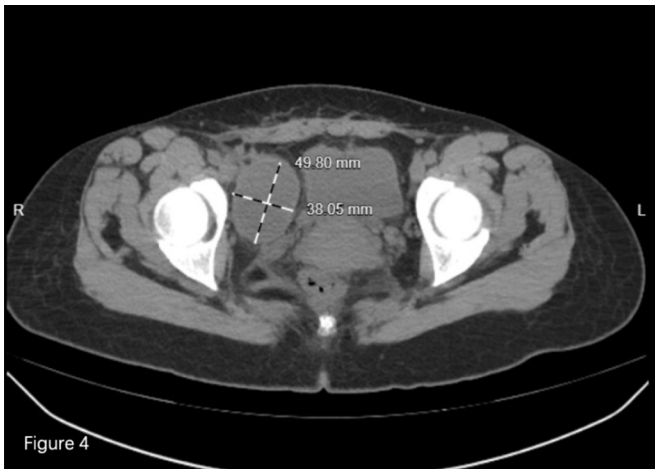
Abdominal CT showed that the pelvic hematoma was significantly reduced two months after surgery.
